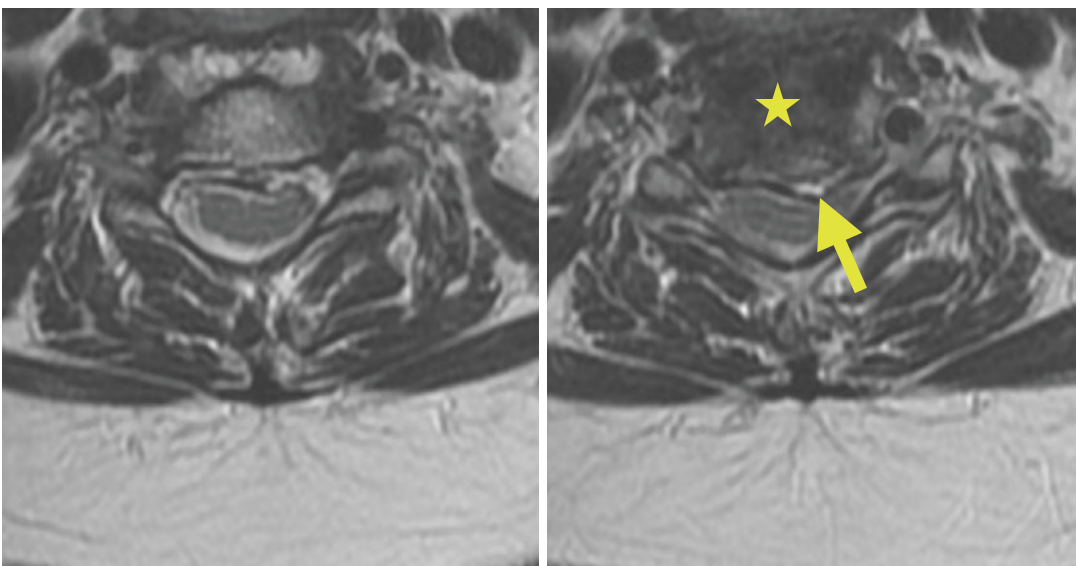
Axial T2-weighted images of the cervical spine demonstrating a diffuse disk bulge (star) with a superimposed left paracentral disk protrusion and annular fissure (arrow)
